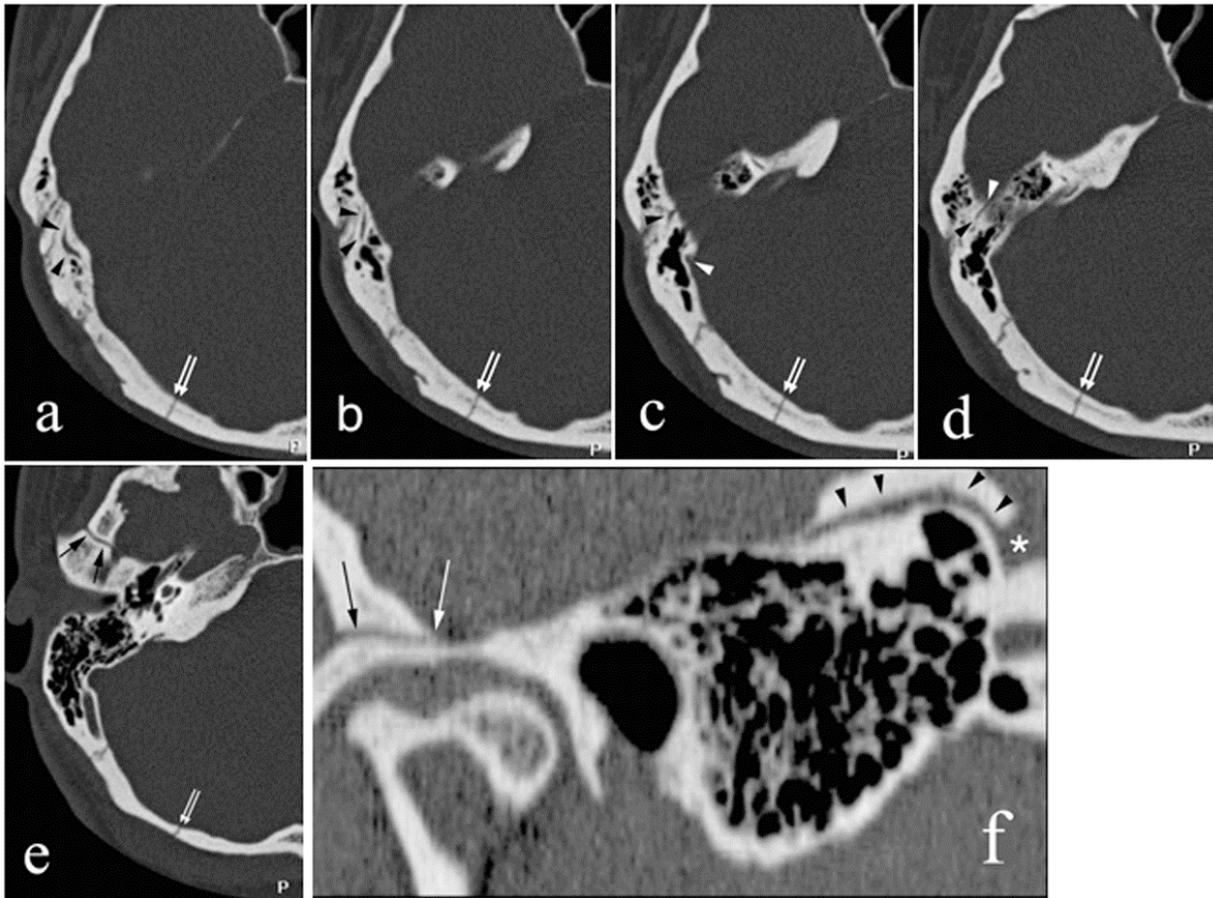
Case 1. High resolution CT with bone algorithm of the right temporal bone (Philips MX 8000 IDT 16 channel-multirow detector, Philips Medical Systems, Best, The Netherlands). 26a-e are axial source images following the course of the PSS cranio-caudally. The proximal and dorsal portion of the PSS is contained within a petrous bony canal (arrowheads) that is parallel to the petrosquamosal suture and follows the roof of the left petrous bone (26a-d). Proximally, the petrous bony canal opens into the superior and lateral aspect of the distal transverse sinus (white arrowhead, 26c) Distally, it opens into the middle cranial fossa, where the PSS likely shifts from a diploic to a dural position (white arrowhead, 26d). A bony canal in the temporal squama containing the anterior and lateral branch of the PSS is depicted in 26e (black arrows). This temporal canal is anterior to the root of the zygomatic process and cranial to the glenoid cavity of the temporomandibular joint. Its opening into the temporal fossa corresponds to the PGF. Thus, in this case, the portion of the PSS coursing on the floor of the middle cranial fossa is intradural and not intraosseous, while its proximal (dorsal) and distal (ventral) extremities are contained in the petrous and temporal squama, respectively. A linear fracture of the occipital squama is seen on all images (white double arrow). 26f shows a curved MPR reconstruction of the osseous canals containing the PSS. The arrowheads indicate the petrous canal containing the proximal PSS; the arrows point at the temporal canal containing the medial and anterior branch of the PSS.
